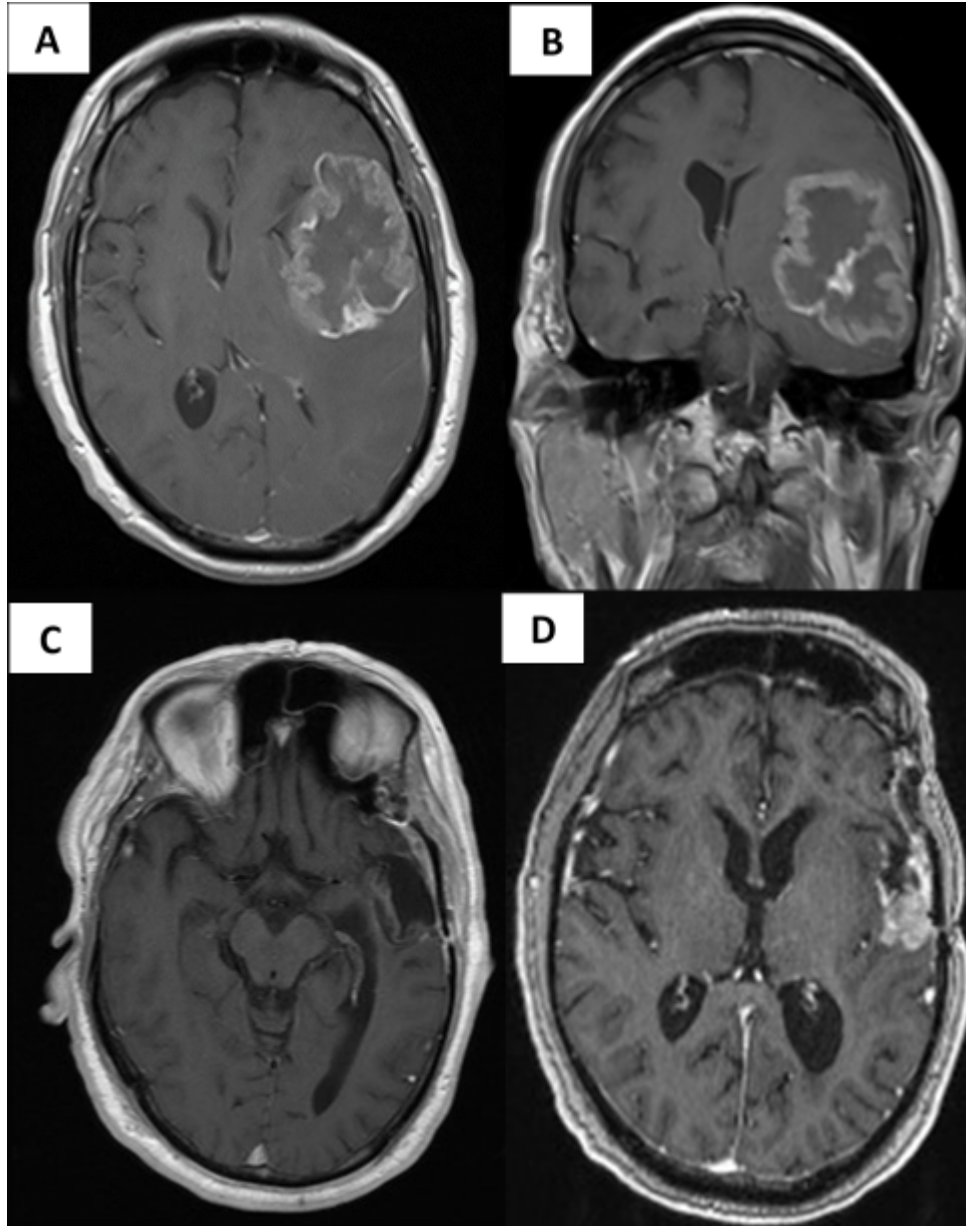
MRI images of local recurrent glioblastoma. A and B.) Axial and coronal MRIs at the initial diagnosis of GBM, respectively. C.) MRI scan showing the surgical cavity following initial resection. D.) MRI acquired at the time of symptomatic recurrence, 7 months after initial surgery.
